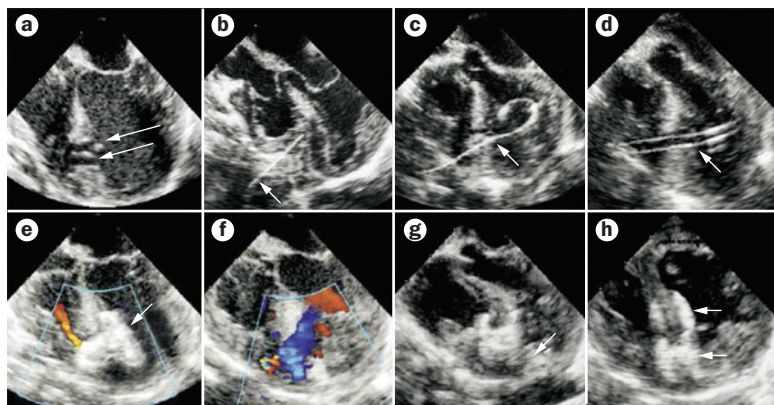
Periventricular closure of a complex mid-muscular ventricular septal defect. The procedure is performed off-pump on the beating heart under transoesophageal echocardiography guidance. a | Identification of the defect (arrows). b | A needle (arrow) is introduced through the right ventricular free wall. c | A wire (arrow) is passed through the needle into the left ventricle via the ventricular septal defect. d | A sheath (arrow) is introduced with the tip positioned into left ventricular cavity. e | The first umbrella device (arrow) is positioned. f | A residual shunt (blue area) is noted. g | A second device (arrow) is positioned using the same technique. h | Complete eradication of the shunt. The two arrows indicate two separate devices. Reprinted from *Semin. Thorac. Cardiovasc. Surg. Paediatr. Card. Surg. Annu.*, 8(1), Bacha, E. A. *et al.*, Hybrid procedures in paediatric cardiac surgery, 78–85, © (2005), with permission from Elsevier.
